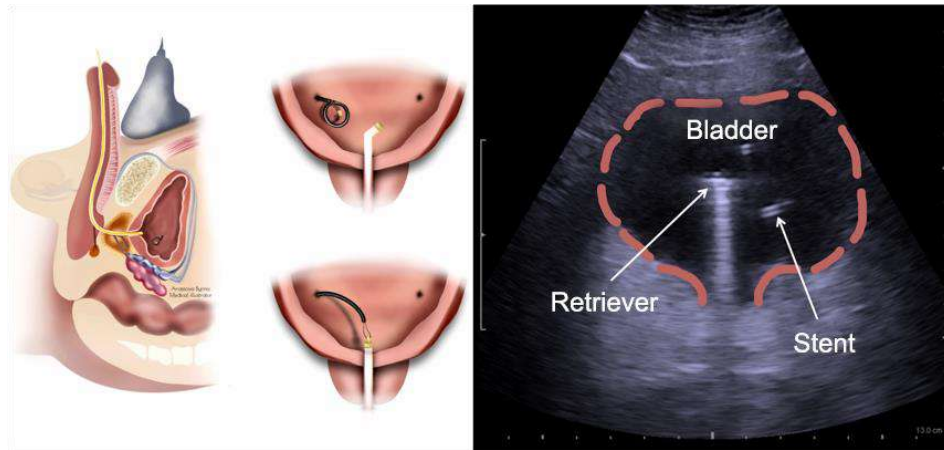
Ultrasound transducer placed along the midline of the suprapubic region and ultrasound image showing hyperechogenic magnetic parts of the stent and retriever
